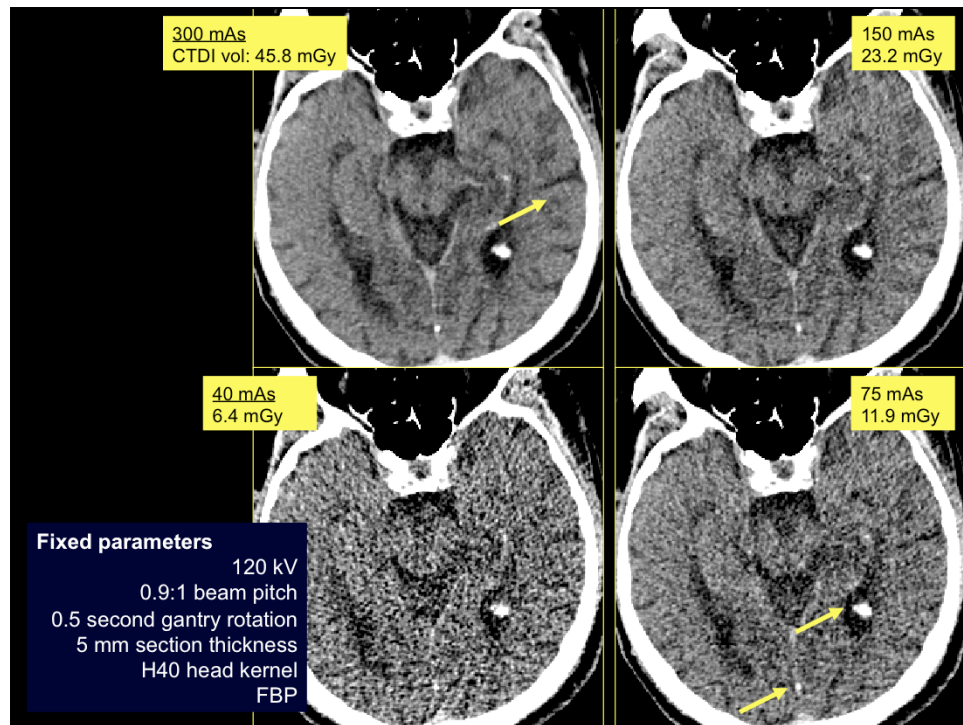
Post mortem head CT acquired at various tube currents shows increased image noise in low dose images, which affects the delineation of low contrast structures, such as, sulci and gyri (arrow) while retaining the visibility or detection of high contrast small structures, such as choroid plexus (arrow) and calcified spec in the posterior falx (arrow).
